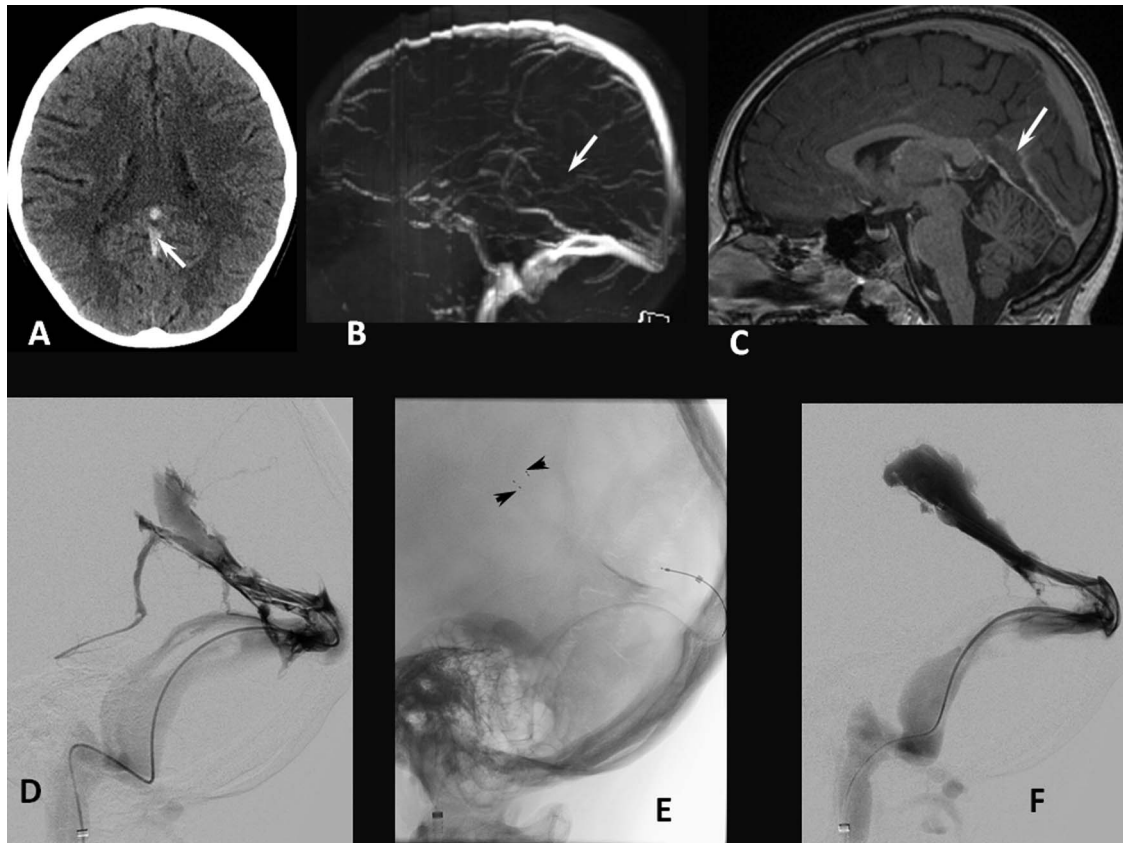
(A) Axial unenhanced CT showing hyperdense clot within the vein of Galen and straight sinus (arrow). (B) Sagittal reconstruction of two-dimensional time-of-flight MR venography with no visible flow-related enhancement within the expected location of the vein of Galen or straight sinus (arrow). (C) Sagittal T1 MPRAGE post-contrast imaging showing non-enhancing thrombus within the vein of Galen and straight sinus (arrow). (D) Straight sinus venography (lateral view) showing poor filling and intraluminal filling defects compatible with thrombosis. (E) Lateral view after deployment of the Solitaire FR device (arrowheads). (F) Straight sinus venography (lateral view) showing complete filling and rapid washout following thrombectomy.
